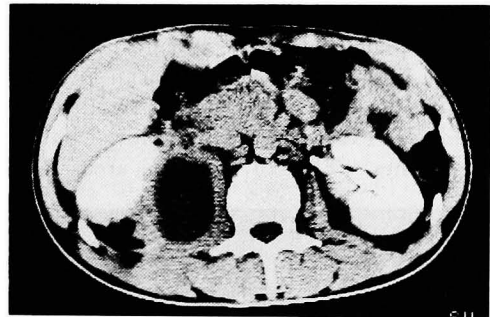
Low density area in the right psoas muscle of Case 1 shown by CT scan
